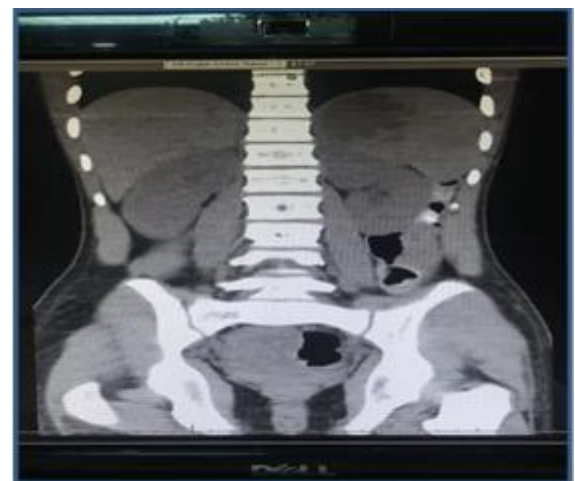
Patient CT- abdomen
